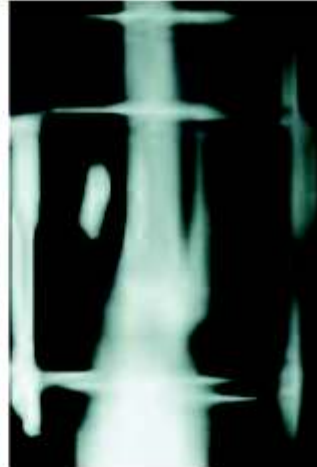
Fig K — Postoperative X-Ray
